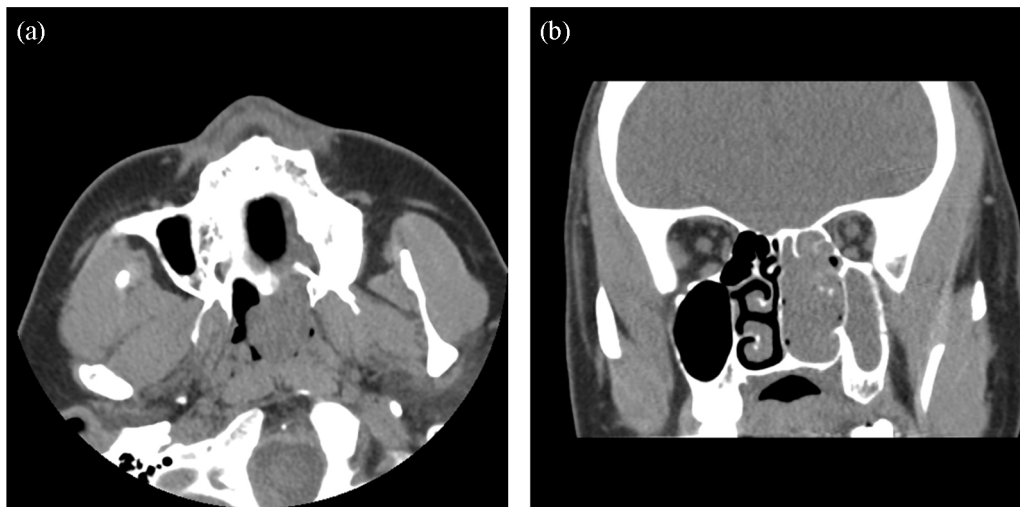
(a) Axial unenhanced CT image of the face demonstrates a soft tissue mass in the left sphenoid sinus. (b) Coronal CT image of the face demonstrates opacification with a soft tissue mass within the left maxillary sinus and osteomeatal units.
